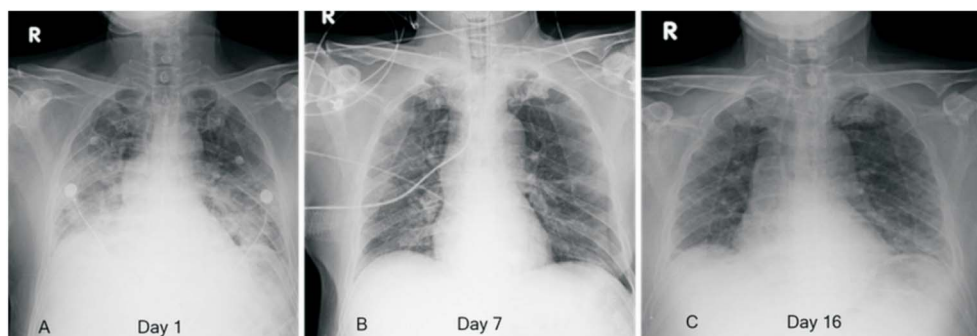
(A) Chest radiography performed on day 2 showing prominent bilateral infiltrations and ill-defined patchy opacities in the right and left lungs, suggestive of acute respiratory distress syndrome. (B) Chest radiography performed on day 7 showing obvious resolution of the bilateral opacities. (C) Chest radiography performed on day 16 shows marked improvement.
